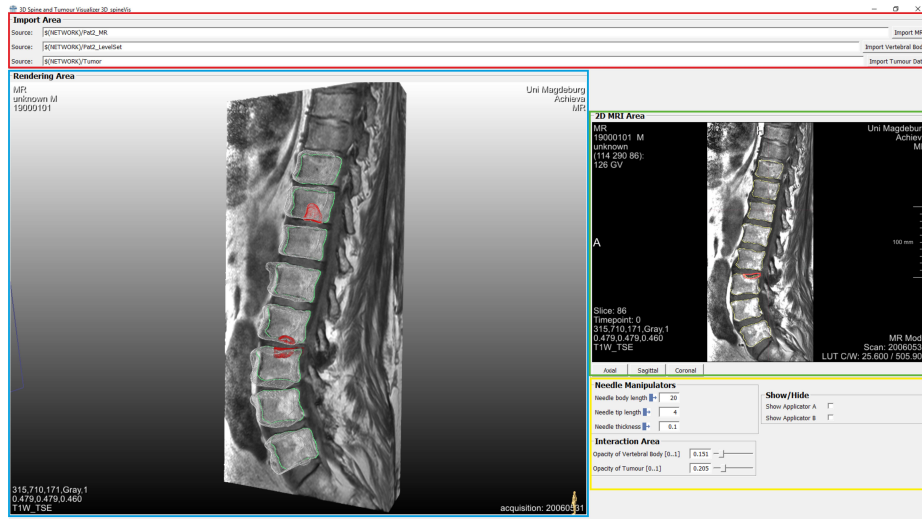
The GUI of our prototypal “3D-SpineVis” application. On the top one can import the MRI or CT scans and the corresponding vertebral body and tumor/metastases segmentations (red box). The large viewer on the left is for spatially exploring the volume-rendered scene (blue box). Herein, a clinical expert could comprehensibly explain patient-specific spatial relations and give insight how to perform an ablative intervention with interactive models of minimally invasive applicators. On the upper right, both the original image data with super-imposed segmentation contours could be explored and the applicator models could be placed here per one-click (green box). In the yellow box in the lower right corner opacities of the segmented 3D objects could be adjusted (vertebral bodies in white, metastases in red), and it offers the option to show or hide the applicator models.
